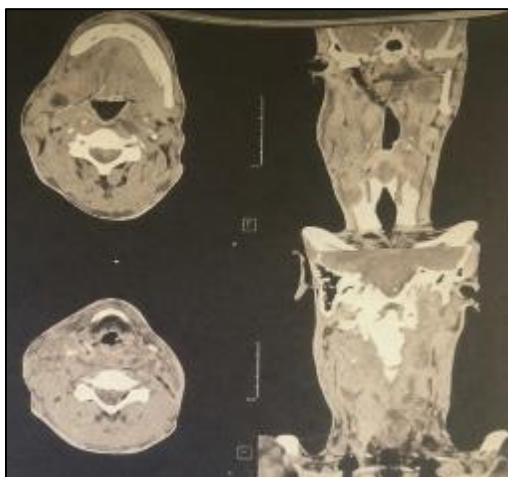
Axial and coronal cervical CT images demonstrating hypopharyngeal wall thickening extending to the upper esophagus, bilateral cervical lymphadenopathy, and associated retropharyngeal abscess formation predominantly on the left side
